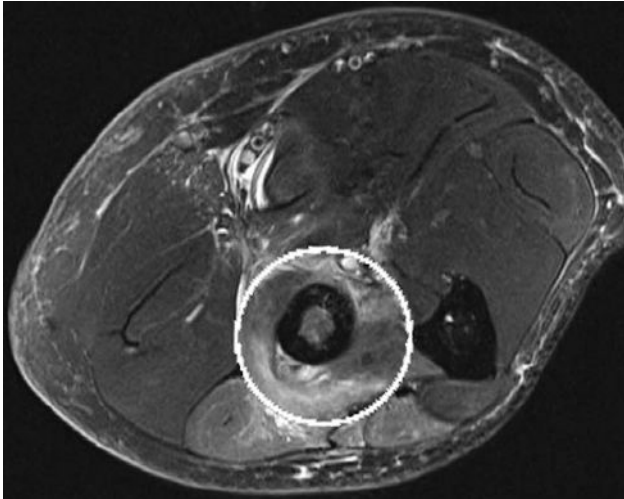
Axial fat suppressed intermediate signal MR image demonstrates increased signal of the supinator and extensor muscles (circled).
